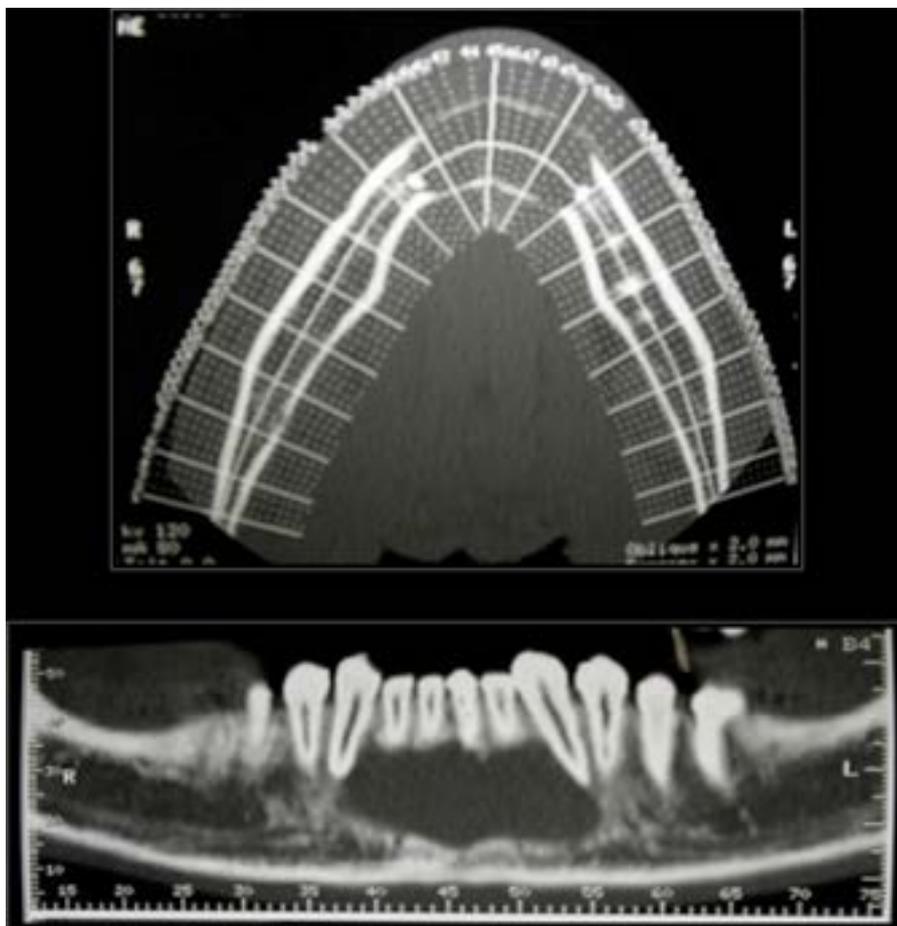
3D radiographic exam with disappearance of the outer and inner cortex of the mandible.
